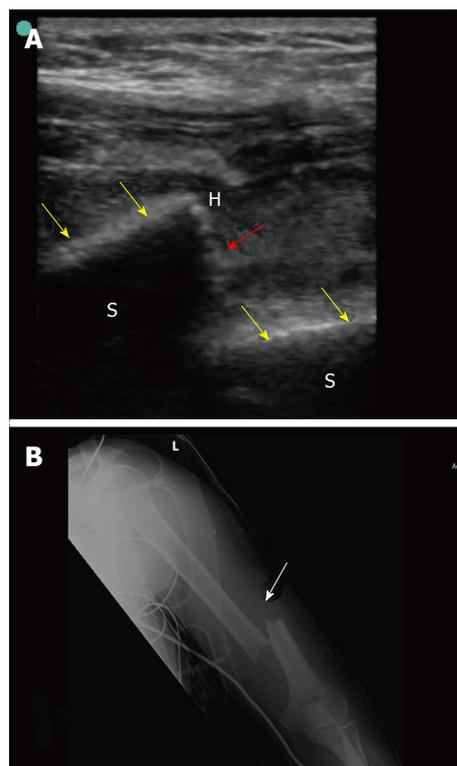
Point-of-care ultrasound of a 42-year-old laborer who fell from 8 meters high during work. The patient presented with pain, swelling and deformity of the left arm. He had left wrist drop. B mode point-of-care ultrasound of the humeral shaft using a linear probe having a frequency of 10-12 MHz (A) showed that the white cortical line of the humeral shaft (yellow arrows) has been interrupted by a large gap (red arrow) suggesting a displaced fracture at the shaft. X-ray of the humerus (B) confirmed the presence of a displaced fracture (white arrow). S: Sonographic shadow of the humeral shaft; H: Hematoma at the edge of the fracture. Ultrasound study was performed by Professor Fikri Abu-Zidan, Department of Surgery, Al-Ain Hospital, Al-Ain, UAE.
